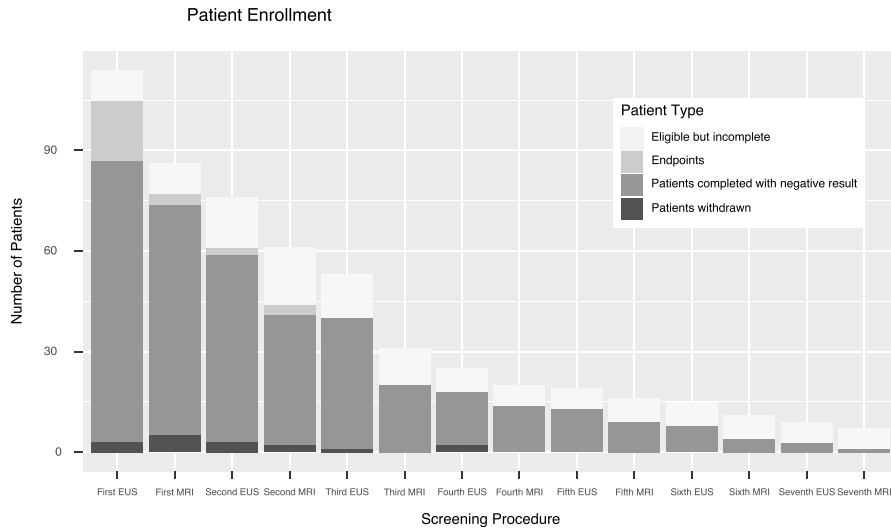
Patient enrollment. Patients alternated between EUS and magnetic resonance imaging (MRI) as screening modalities. Frequency of screening was determined by risk factors for developing PC. Patients enrolled into the study at different times over the 5-year period. As a result, patients have been eligible for a varying number of screening tests. “Eligible but incomplete” represents patients who are within the time frame of their test, and have not yet completed. “Endpoints” represents positive screenings.
